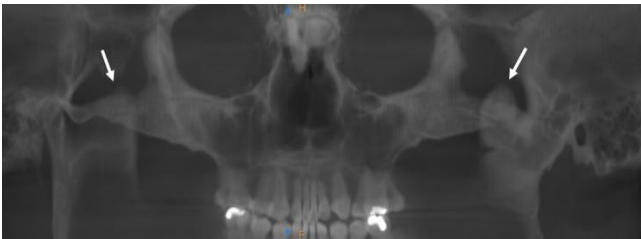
Panoramic reformation with CBCT showing both coronoid processes are elongated (arrows).
